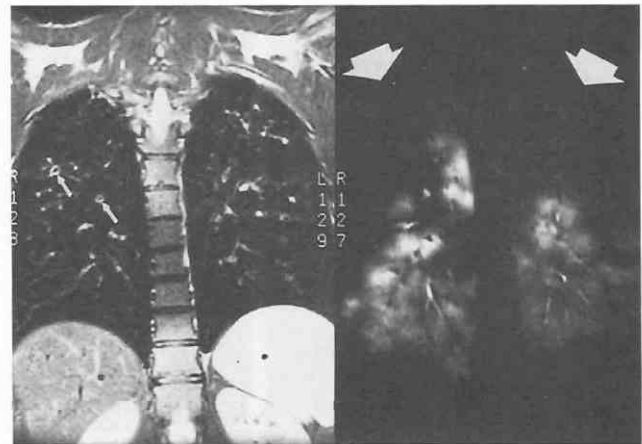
Hyperpolarized helium 3-enhanced MR image of the lungs in a patient with cystic fibrosis. *Left*, A fast spin-echo (TR, 2857; TE, 80) coronal image through the posterior lung shows minimal peribronchial thickening demonstrated as linear high-signal areas (small arrows). No other morphologic changes of cystic fibrosis are present. *Right*, MR image obtained after the patient was ventilated with a single breath of hyperpolarized helium 3 demonstrates the absence of ventilation throughout the majority of the upper lobes (arrows). High-signal areas represent ventilated lung. The high signal intensity on the left should be distributed throughout the lung.
